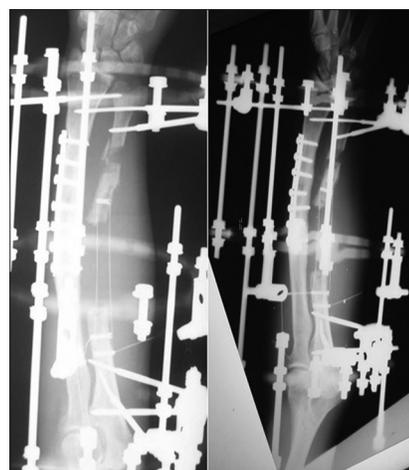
After closure of the wound, forearm was stabilized in a circular fixator and lengthening osteotomy was performed percutaneously. Early postoperative anteroposterior radiographs of forearm of Patient 1 revealed an effective bone transport following 5 days of latency period and 10 days of bone transport
